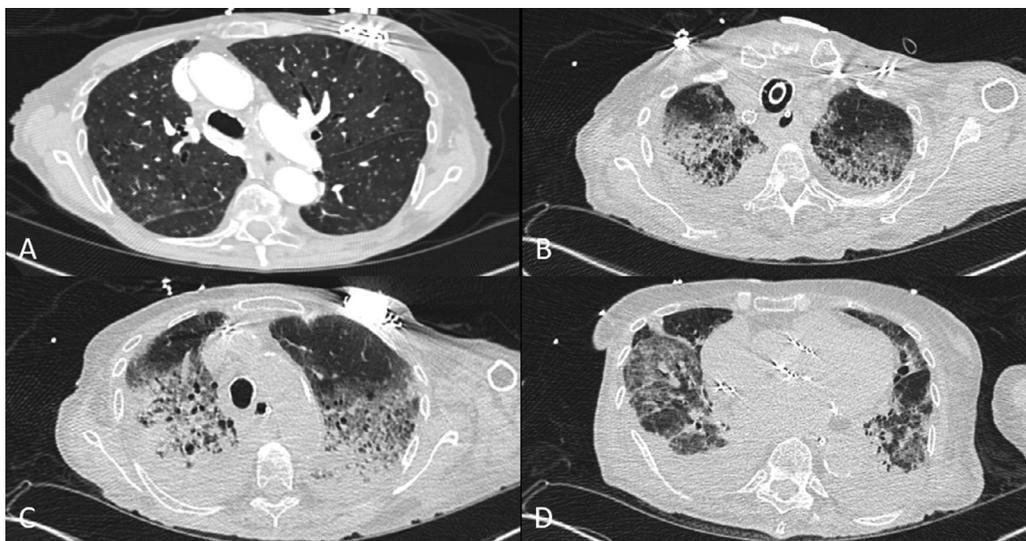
Progression of acute lung injury by serial computed tomography (CT) scans. Panel A: Preoperative chest CT scan serves as a clinical baseline. Panels B-D: Chest CT scan on the 12th postoperative day shows the lung fields in a cross-sectional fashion. There are extensive alveolar infiltrates with areas of consolidation throughout the lung fields.
